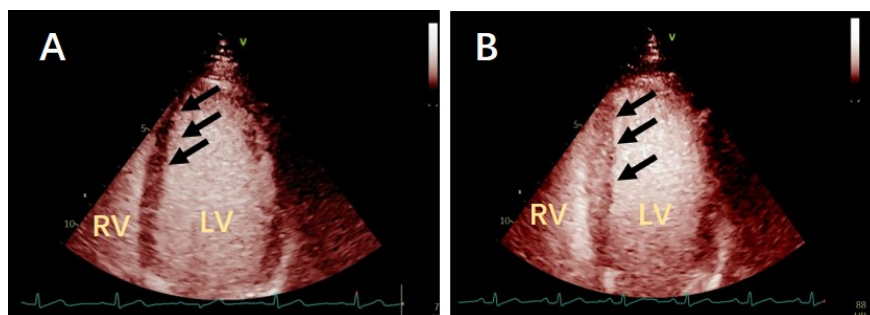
Transthoracic apical 4-chamber view, MCE showed "abnormal reperfusion" at the apex/mid of the ventricular septum, that is, there was a delayed perfusion defect in the apical/mid ventricular septum before ATP stress (A) (After "flash" for 5 cardiac cycles) (black arrow). At the ATP peak stress (A), myocardial perfusion was significantly improved at the same position (Within "flash" for 2 cardiac cycles) (black arrow).
